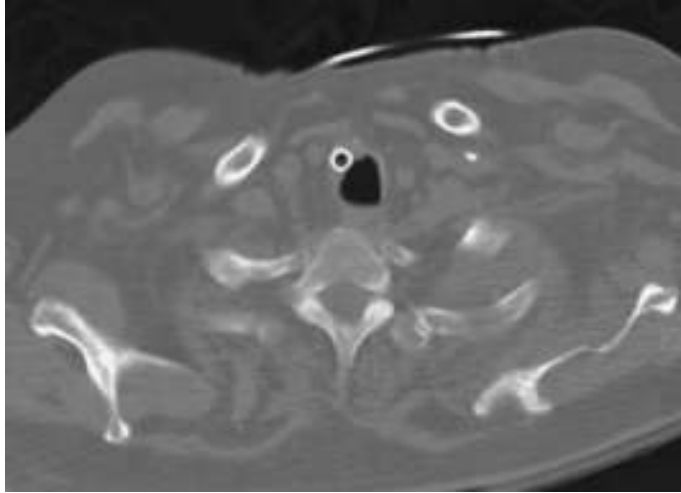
CT scan image through the torso demonstrating the tracheostomy tube in a false passage outside of the trachea.
